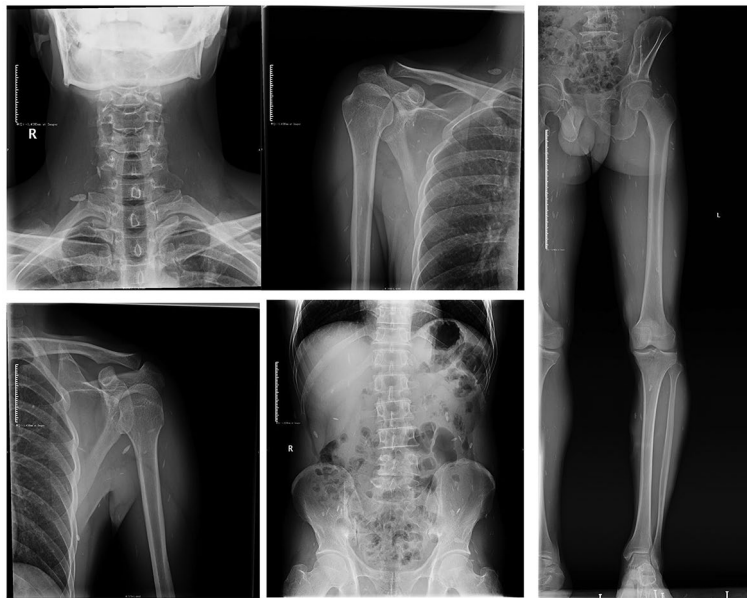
Whole-body X-ray slices. Whole-body X-ray reveals multiple elliptical and elongated high-density lesions within the soft tissues throughout the body, consistent with clinical suspicion of cysticercosis
